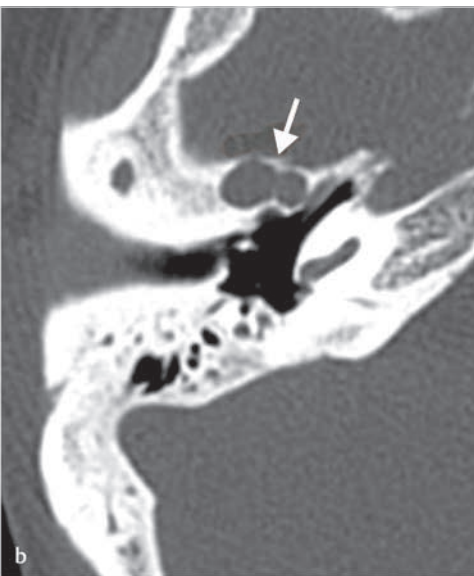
The axial CT (a) shows infiltration of the cholesteatoma to the superior semicircular canal (black arrow) reaching the area close to the fundus of the internal auditory canal (red arrow). The CT at the level of the basal turn of the cochlea (b) shows anterior extension of cholesteatoma (white arrow) without involving the mesotympanum.
